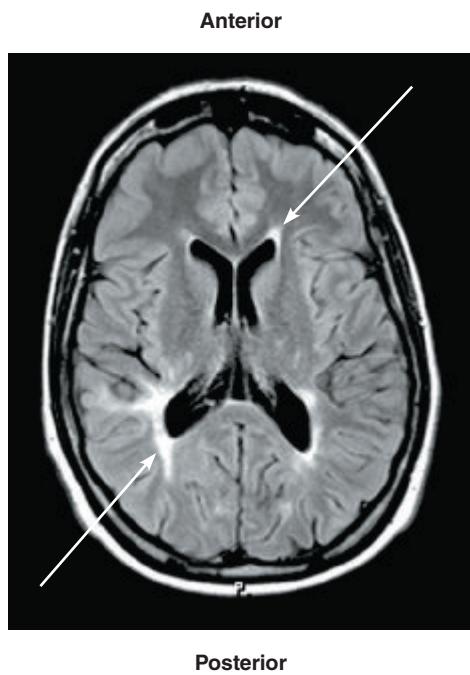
Multiple sclerosis. MRI of the brain of a patient with MS, transverse section. Lesions appear as bright white spots within the white matter.
